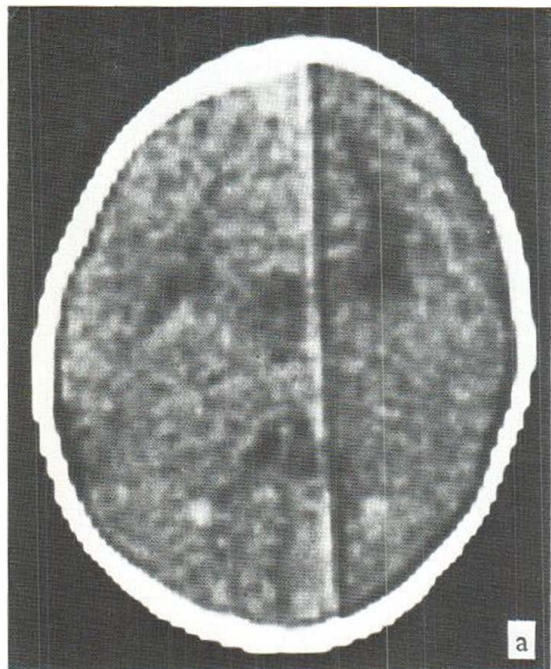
a* and *b*. The dense masses in prefrontal tissue are clearly visible in computed tomography (CT) at the age of 3 months.
